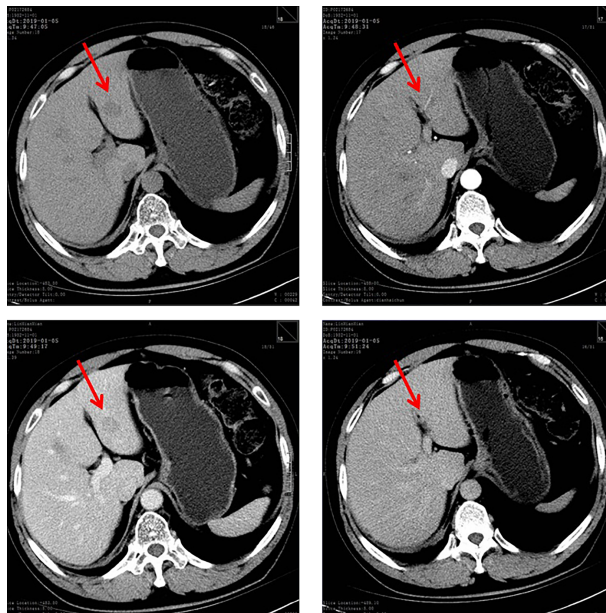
Abdominal computed tomography (CT) images. A, non-contrast CT image; B - D, dynamic contrast-enhanced CT images; B, arterial phase image; C, portal phase image; D, delayed phase images.
